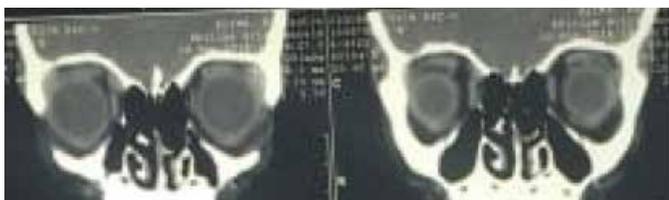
MRI Showing resolution of lesion in right Superior Oblique
